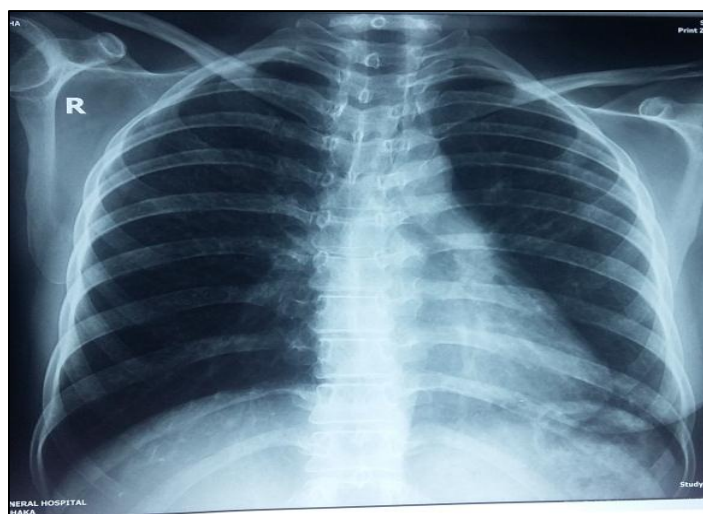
X-ray chest showing normal findings after six weeks of treatment withTMP-SMX
